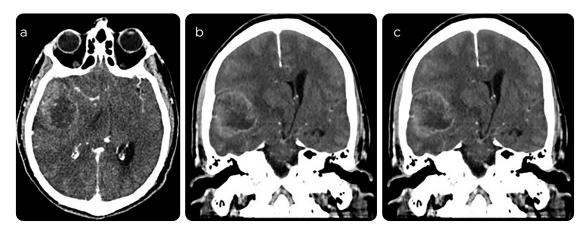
Skull CT with contrast medium. a) Axial section with reconstructions b) coronal and c) sagittal. Right temporal intraaxial lesion, amorphous, of low density in relation to the cerebral parenchyma with dimensions of $35 \times 50 \times 35$ mm in its longitudinal, anteroposterior and transverse axes. It shows peripheral enhancement and mass effect on the frontal lobe, with decrease in width and depth of the grooves and clefts, the frontal shaft and body of the lateral ventricle, the basal ganglia and the ipsilateral thalamus, with deviation of the midline of up to 15 mm.
